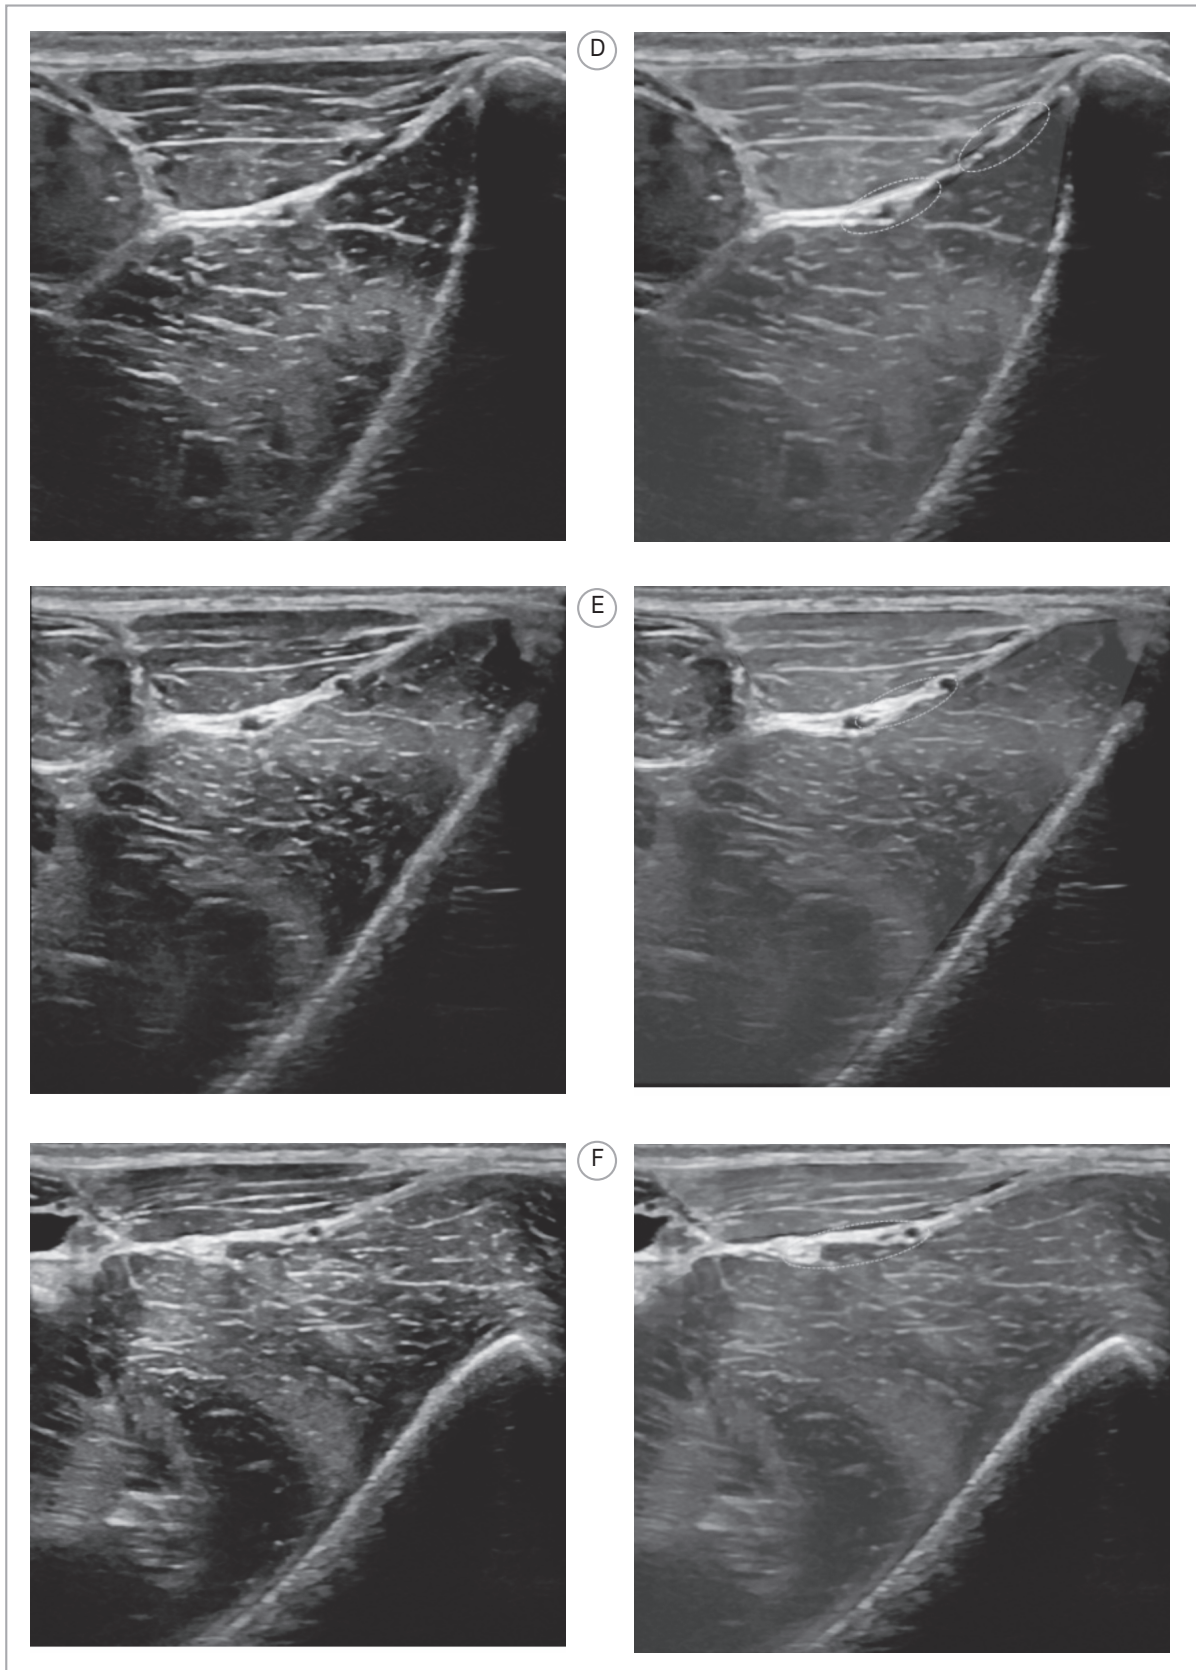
Ultrasound examination of the II / IH nerve course of the presented case (red - iliopsoas muscle; orange - lateral abdominal wall muscles; dotted circles – II / IH nerves).
